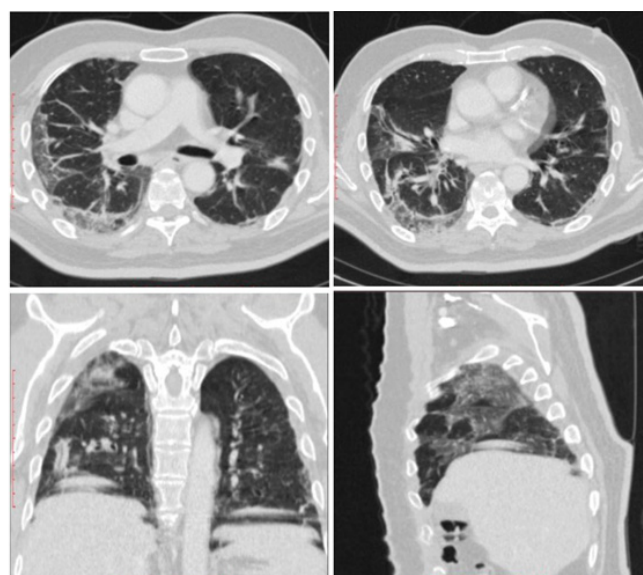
CT scan thorax case 2 on 46th day of illness.
